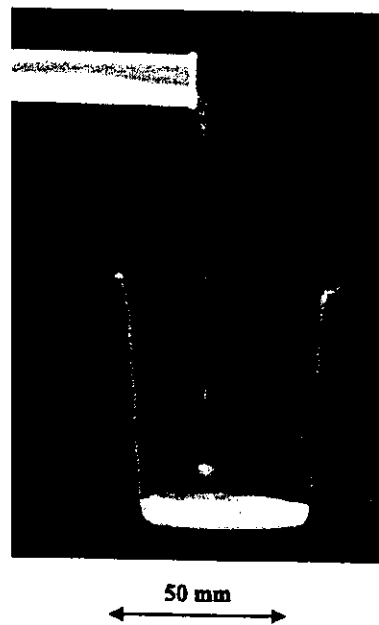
Radiogram of water falling into a polypropylene beaker from a glass test tube. The stop-motion image of water was obtained by monochromatic flash radiography.
